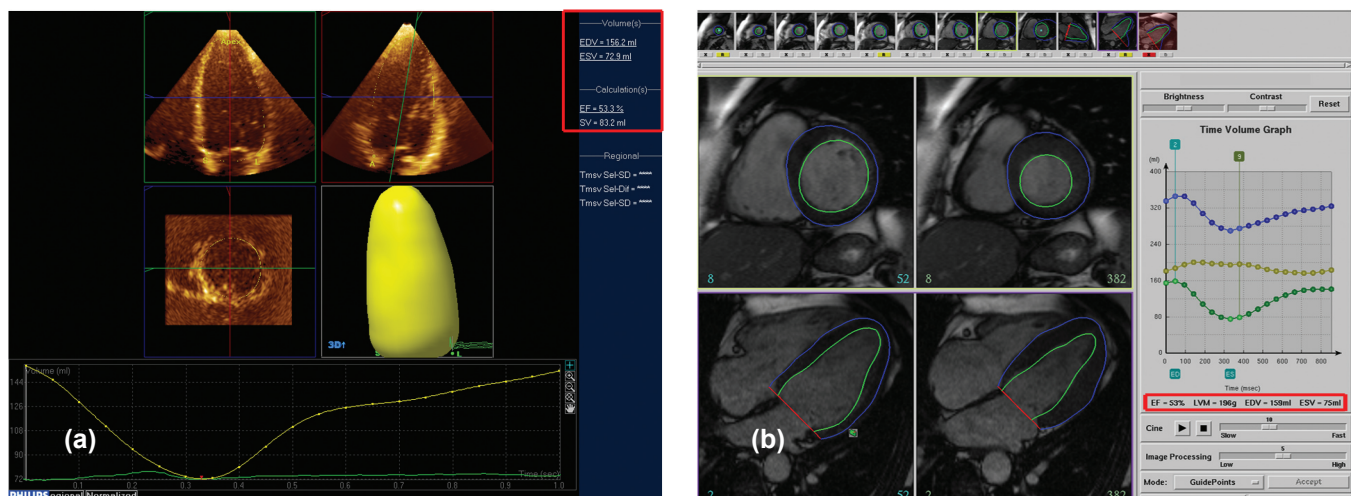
Comparison of 3DE and MRI LV volume and EF measures. (a) 3DE global time volume curve (QLab, Philips, Andover). (b) MRI global time volume curve (CIM, Auckland University).
